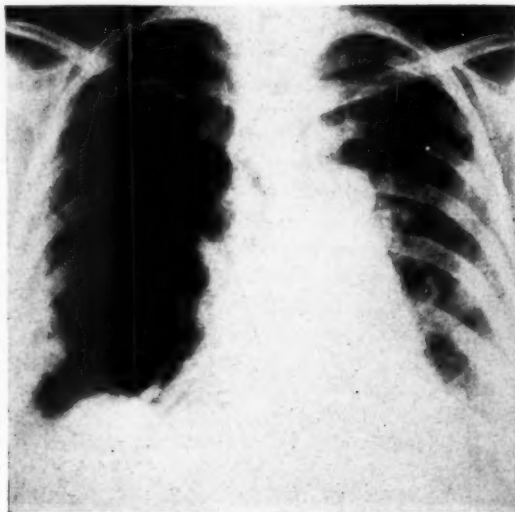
Roentgenogram of the chest of a woman of forty-seven years, showing spontaneous pneumothorax on the right side with metastatic malignancy involving the left lung.
